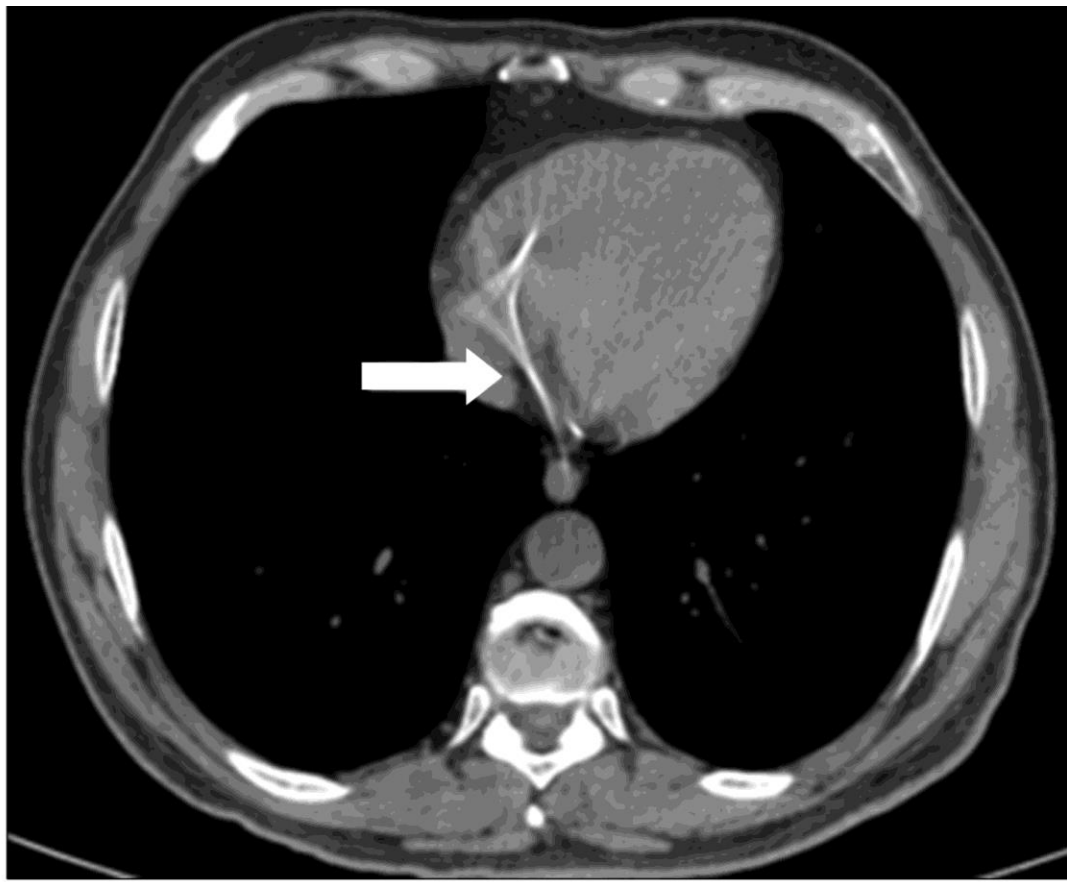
CT image of patient showing fractured catheter embedded into heart⁸.
